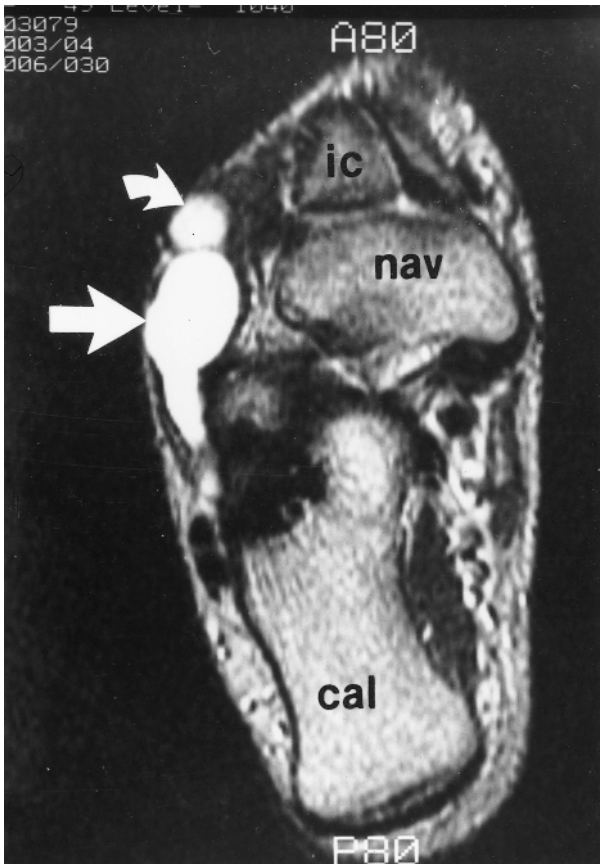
Axial T2-weighted image demonstrates a ganglion cyst on the dorsolateral surface of the foot as associated with the extensor digitorum brevis muscle. ic, intermediate cuneiform; nav, navicular; cal, calcaneus.
